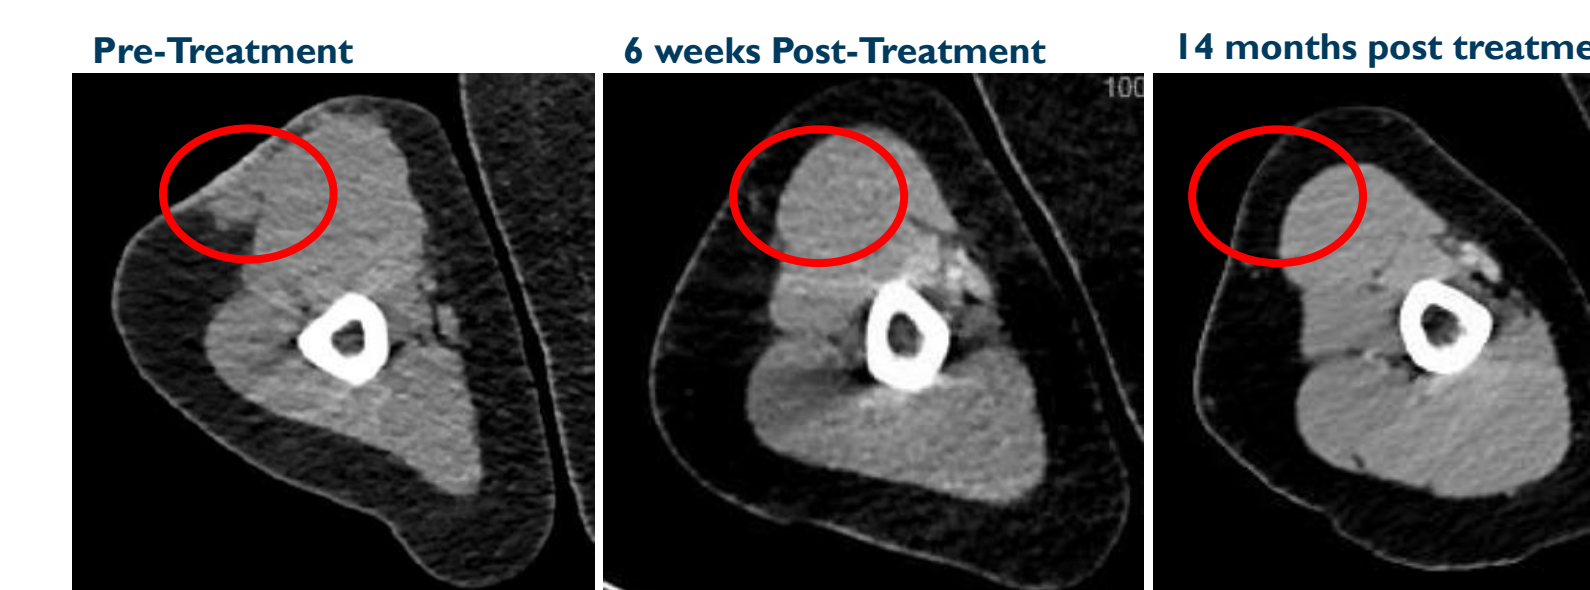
CT Scan for Patient with CR
